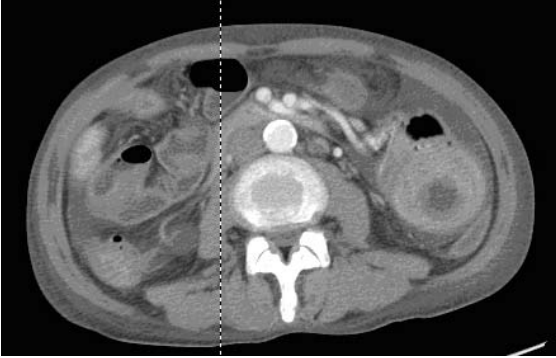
Findings of abdominal computed tomography in fully developed encapsulating peritoneal sclerosis.
